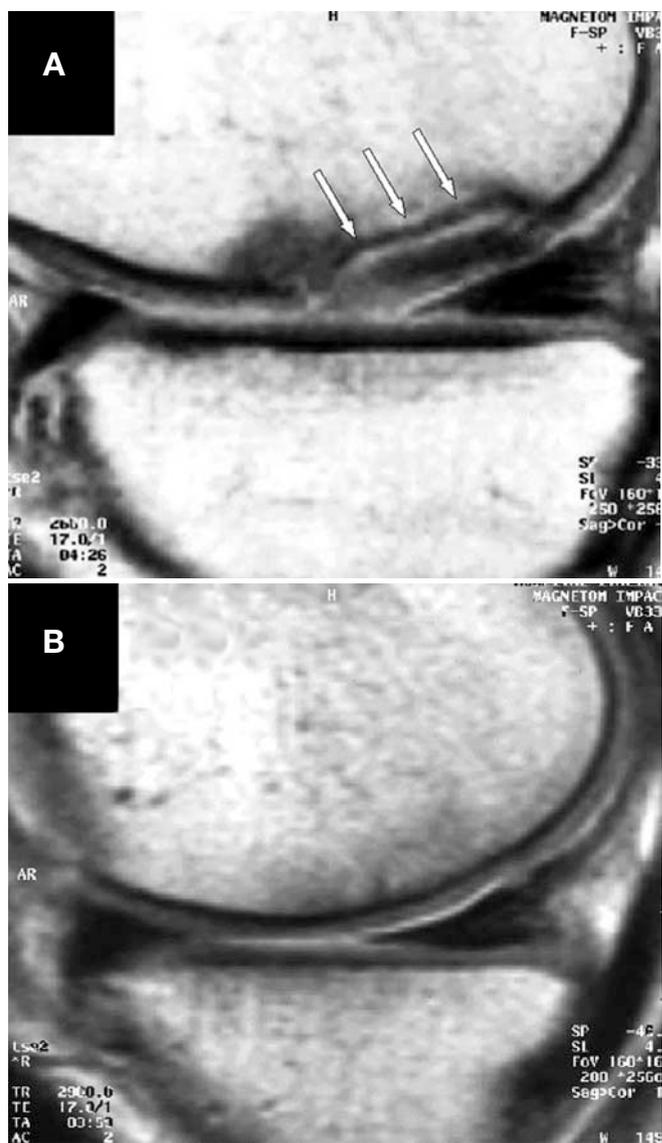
An MRI of the same patient in Figure 1. A, sagittal image of the preoperative MRI. Note the presence of a fluid interface between the osteochondral fragment and the parent bone, which indicates an unstable lesion (arrows). B, sagittal image, made 3 years postoperatively, showing the consolidation of the osteochondral fragment.
